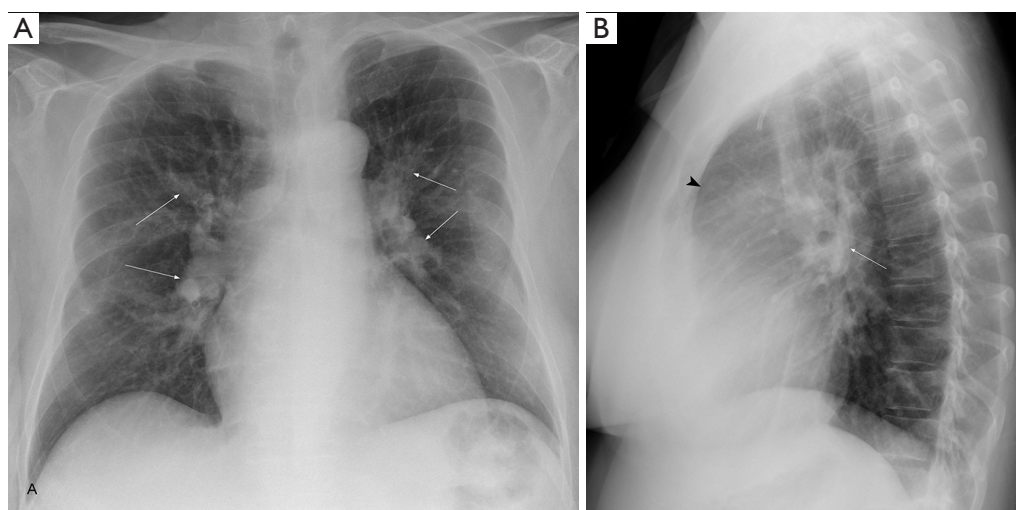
Frontal (A) and lateral (B) view chest radiographs show enlarged central pulmonary arteries (arrows), increased cardiothoracic index and obliteration of the retrosternal clear space (arrowhead).
